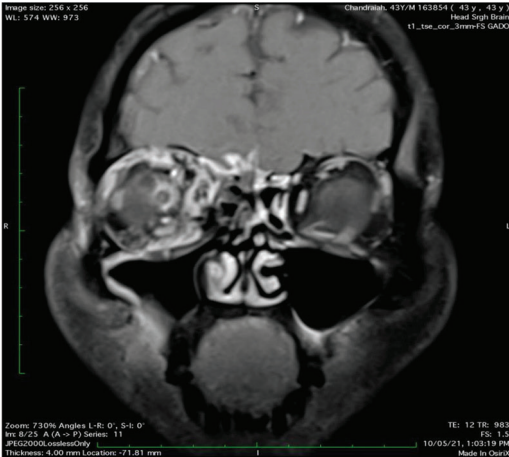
Coronal CE T1 weighted MRI image showing enhancement in intraconal and extraconal compartment of right orbit medial to optic nerve with thickening of medial and inferior rectus muscles and peripheral enhancement of right optic nerve-S/o Orbital invasion in case of Mucormycosis
